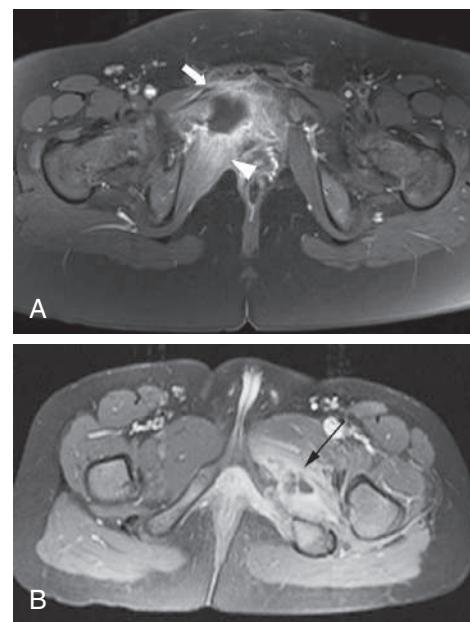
A, Pelvic pyomyositis in a 10-yr-old male presenting with limping. Pelvis MRI demonstrates an avid contrast enhancement of the internal obturator muscle (arrowhead) with an abscess on T1-weighted fat-saturated postcontrast axial image (arrow). B, Pyomyositis in a 7-yr-old male with left pelvic pain and fever. Axial T1 fat-saturated postcontrast image through the inferior ramus of the obturator ring demonstrates multiloculated, rim-enhancing fluid collections in the adductor muscles (arrow), which is characteristic of pyomyositis. (A from Bartoloni A, Gómez A, Pilar M, et al. Imaging of the limping child. *Eur J Radiol*. 2018;109:155–170. Fig 13; B from Pruthi S, Thapa MM. Infectious and inflammatory disorders. *Magn Reson Imaging Clin North Am*. 2009;17:423. Fig 7.)
